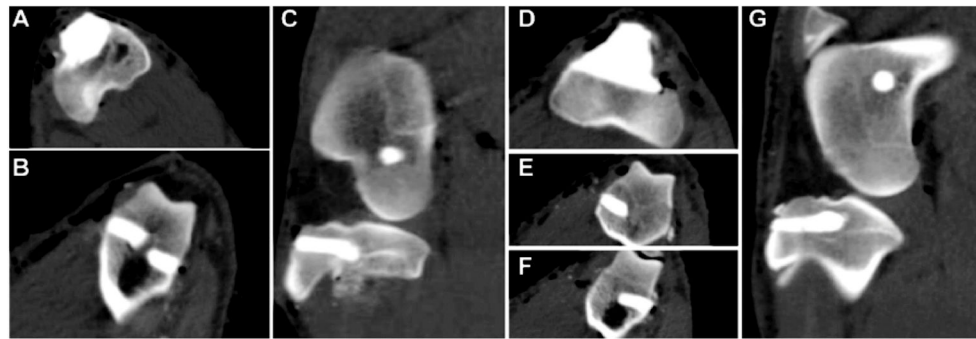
Representative CT images of a CG/nHA-PEUR (A – C) and BGCG/nHA-PEUR (D – G) implant on the day of surgery showing fill of the defects. (A) Axial view of CG/nHA-PEUR tibial plateau defect. (B) Axial view of CG/nHA-PEUR femoral plug defects. (C) Sagittal view of CG/nHA-PEUR tibia plateau and femoral plug defects. (D) Axial view of BGCG/nHA-PEUR tibial plateau defect. (E–F) Axial view of BGCG/nHA-PEUR femoral plug defects. (G) Sagittal view of BGCG/nHA-PEUR tibia plateau and femoral plug defects.
